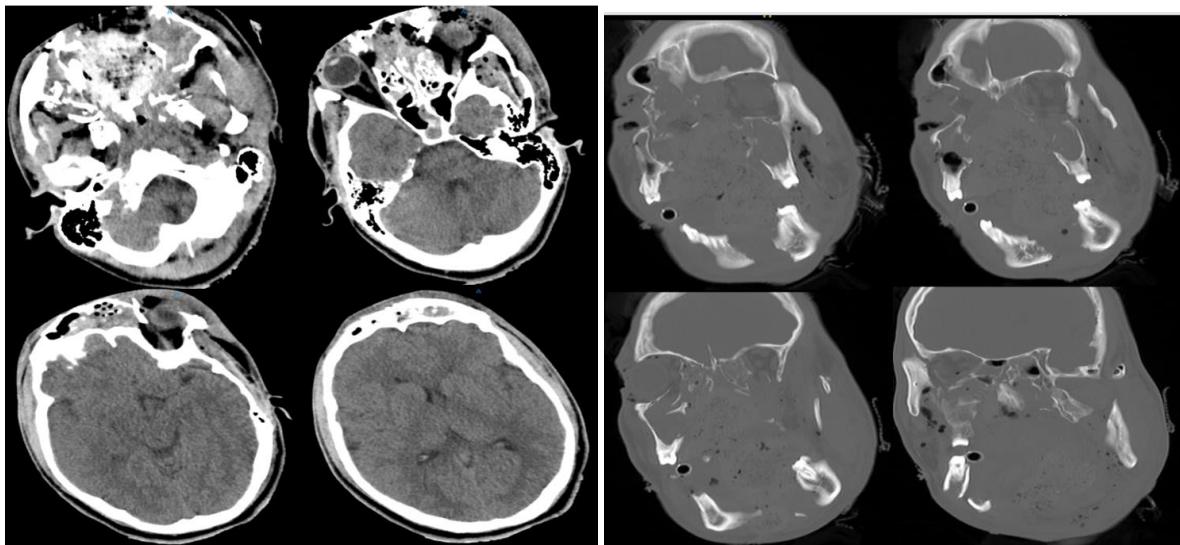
The brain and maxillofacial CT scan showed that the brain parenchyma is normal. Bilateral bone fractures of the frontal and maxillary sinuses with displacement into the sinuses and hematomas are present. Also, the nasal septum and bone, hard palate, pterygoid, maxilla, alveolar process, mandible, and palatine bone had suffered a comminuted fracture. Soft tissue swelling with hematoma and intratissue emphysema is evident.
